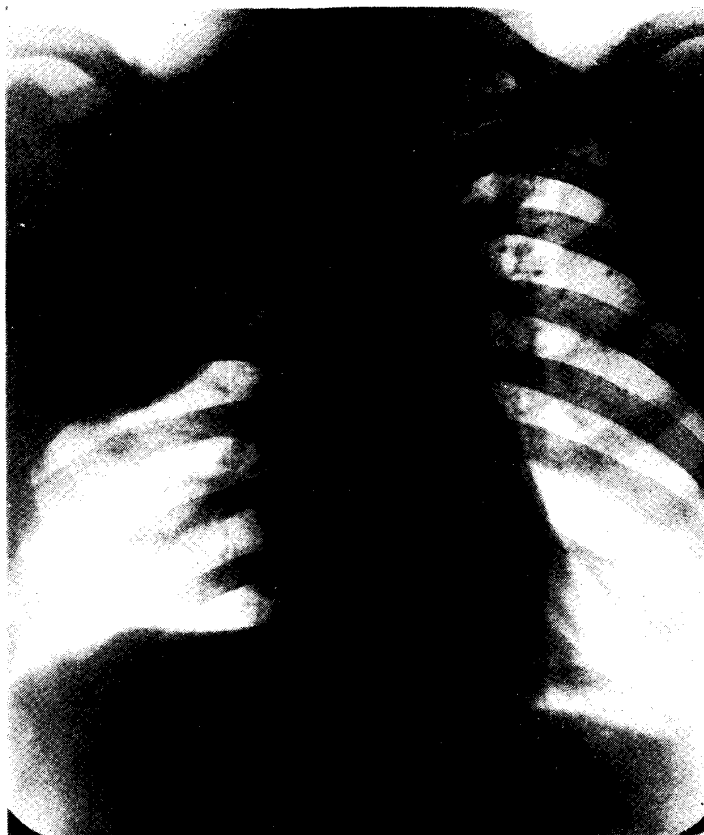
Roentgenogram after plumbage
